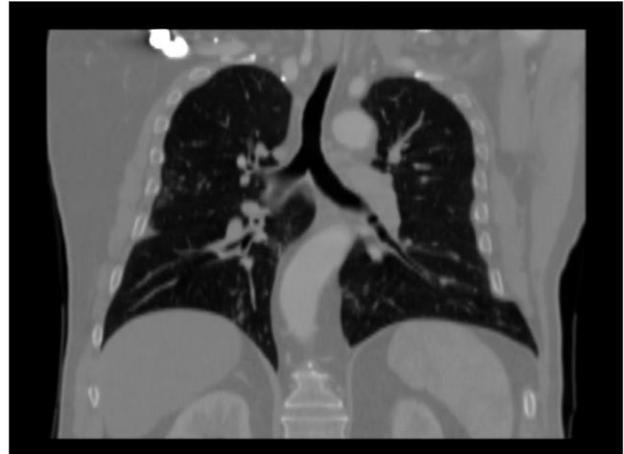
CT scan - coronal plane of lung hernia
